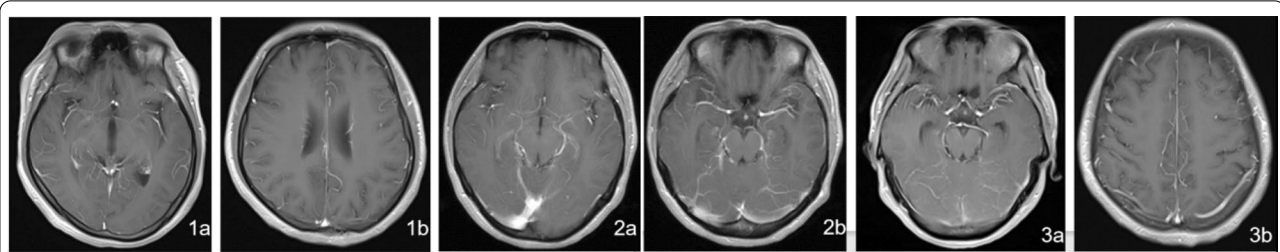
1a and 1b are the axial enhanced T1WI of case I. 2a and 2b are the axial enhanced T1WI of case II. 3a and 3b are the axial enhanced T1WI of case III. The MRI showed increased meningeal enhancement in all three cases
